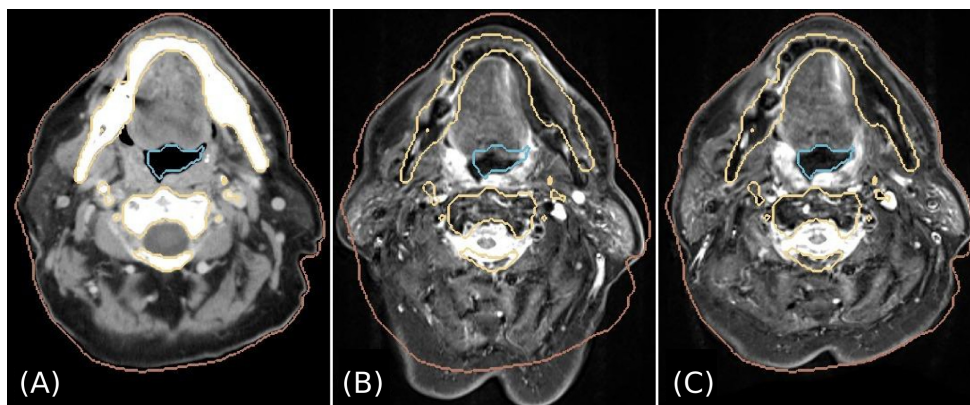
Axial slices of the original CT (A), transformed MR from RR (B) and from DR with LMI+BEP (C) for Patient 2. Contours of skin (brown), bones (yellow) and respiratory tract (blue) derived from the original CT are also shown.
